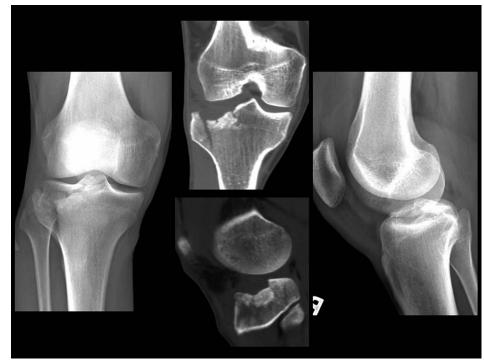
Anteroposterior and lateral radiographs and coronal and sagittal computed tomography images demonstrating Schatzker II tibial plateau fracture, which comprised this study population.
